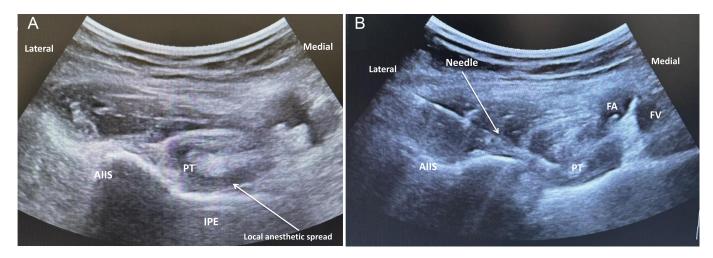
PENG block ultrasound image. (A) Before 20 mL of 0.5% bupivacaine injection; (B) After 20 mL of 0.5% bupivacaine injection. AIIS: anterior inferior iliac spine; PT: psoas tendon; IPE: iliopubic eminence; FA: femoral artery; FV: femoral vein.
